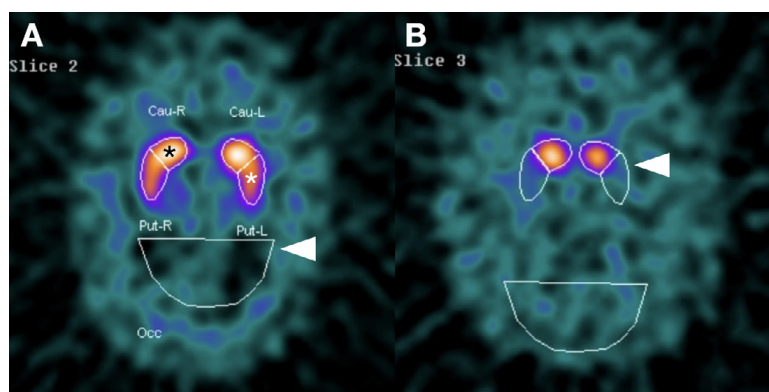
(A) Normal 123I-Ioflupane-SPECT demonstrates a comma shaped appearance of radiotracer uptake in the caudate (black asterisk) and putamen (white asterisk). All readings are relative to uptake within quantitative regions of interest over the occipital lobes (white arrow). (B) Abnormal 123I-Ioflupane-SPECT with reduced uptake in the putamina bilaterally. There is also slightly reduced uptake in both caudate nuclei, in keeping with a grade 3 abnormal study.
